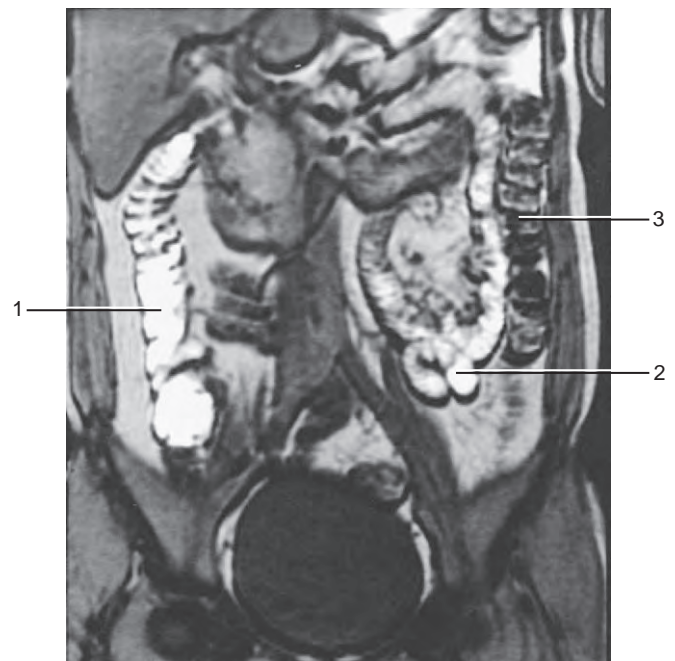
Coronal section of MRI: ascending colon (1), small bowel (2), and descending colon (3).
